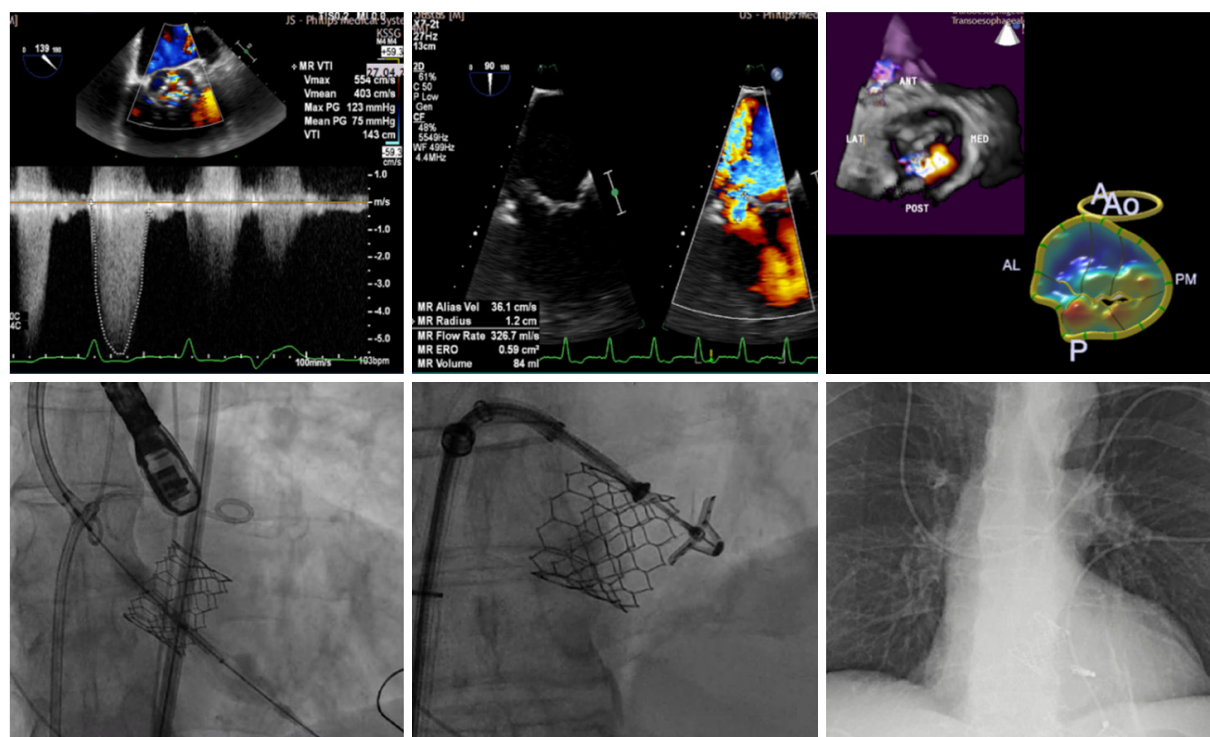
Transcatheter aortic valve implantation concomitant with percutaneous edge-to-edge mitral valve repair in a 70-year-old male patient with severe symptomatic aortic stenosis and severe degenerative mitral regurgitation due to posterior leaflet prolapse (the first 3 images). The procedure was started by the transseptal puncture, followed by transfemoral implantation of a 29-mm balloon-expandable Edwards SAPIEN 3 valve. The last step was MitraClip implantation under transesophageal echocardiogram and angiographic control
